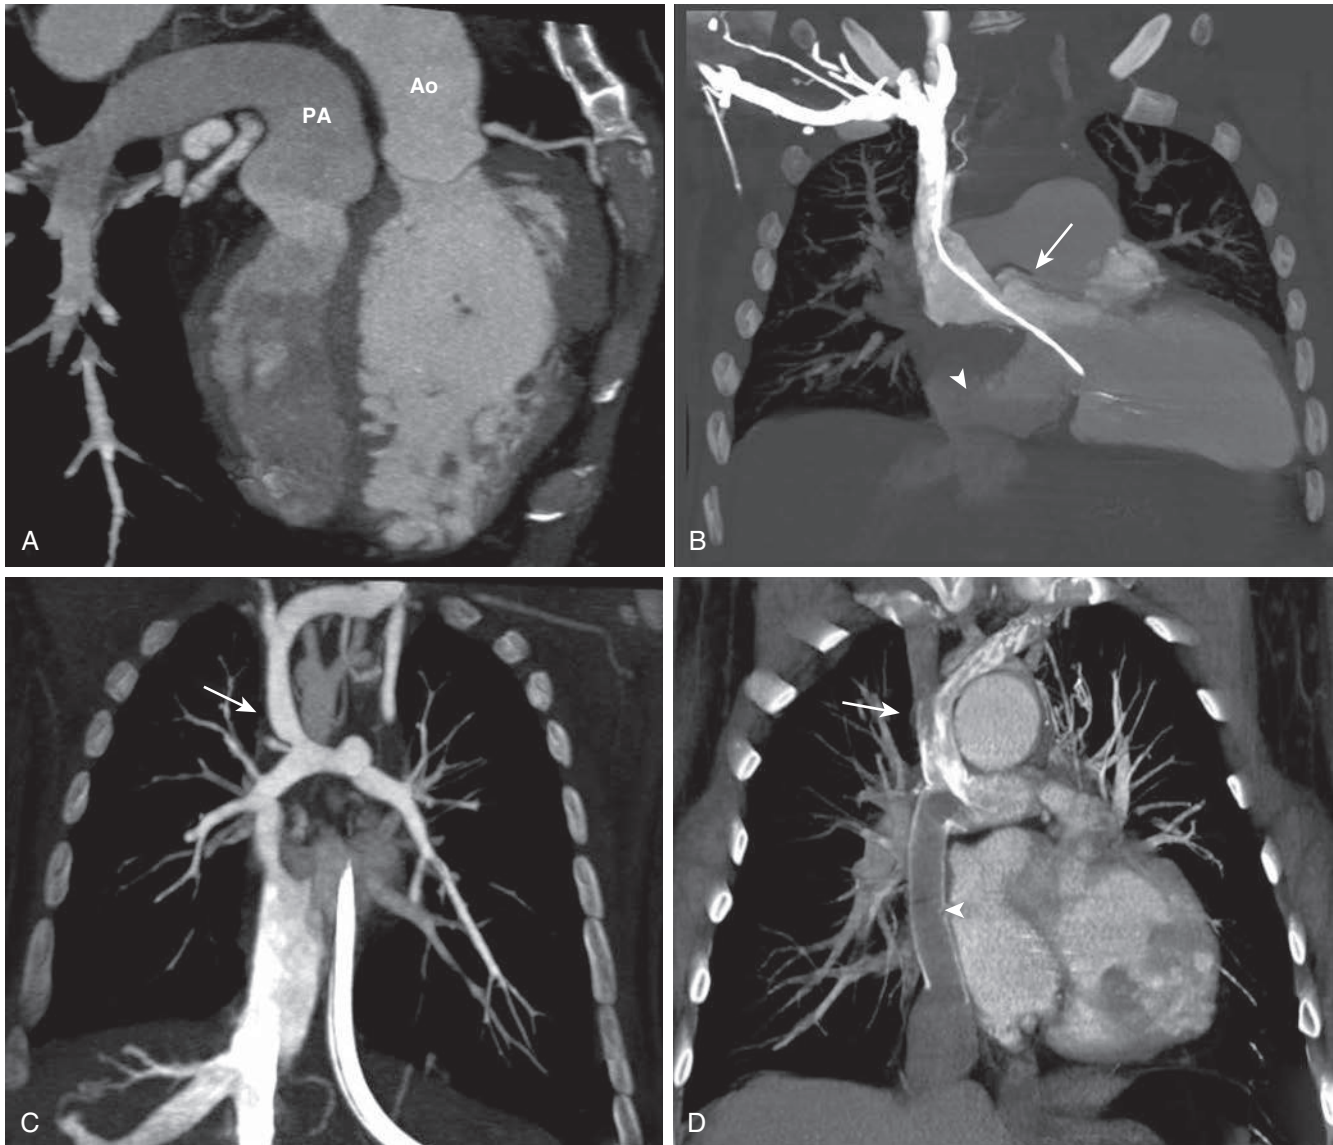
A, Congenitally corrected transposition of the great arteries. The aorta (Ao) can be seen to arise from the trabeculated, morphologic right ventricle, whereas the pulmonary artery (PA) arises from the morphologic left ventricle. B, Mustard repair for transposition of the great arteries. Flow from the superior (arrow) and inferior (arrowhead) venae cavae is directed to the pulmonary ventricle. Note pacemaker lead traversing the superior vena cava channel, which precludes cardiovascular magnetic resonance imaging. C, Glenn anastomosis. The superior vena cava (arrow) is anastomosed to the right PA. D, Total cavopulmonary connection. There is direct anastomosis of the superior vena cava (arrow) with the right PA, whereas the inferior vena cava is connected using a conduit (arrowhead).
